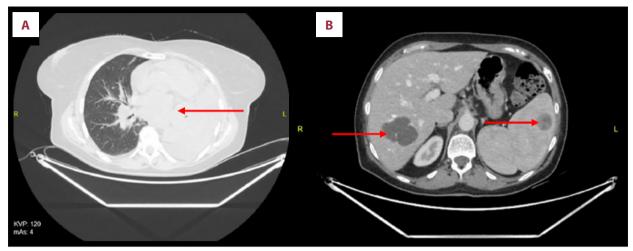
The CT scans of the chest (A: pulmonary window, B: mediastinal window) of a patient with diffused large B cell lymphoma.A) red arrow indicates a solid, extensive nodular and glandular infiltrate with the dimensions around 10-15 cm, remodeling the left lung. B) red arrow denotes lesions suspected of malignancy in the liver and spleen.
